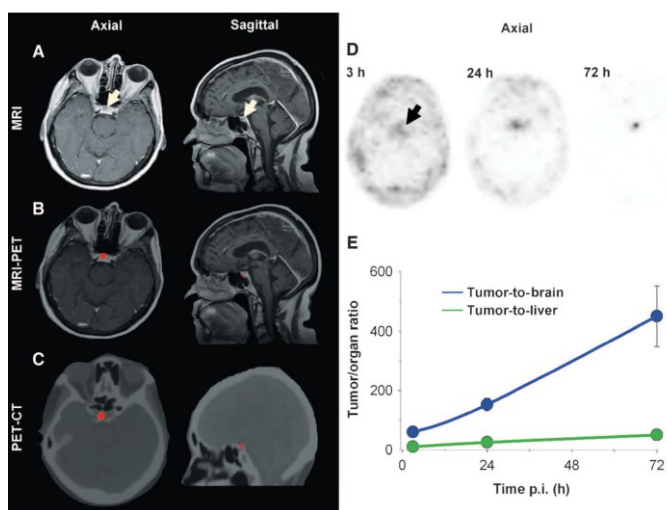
Clinical brain PET scan for ultrasmall inorganic NPs. PET brain scan results from clinical translation of an ultrasmall inorganic optical-PET imaging NP probe. Arrows point to subcentimeter cystic focus (A) imaging 72-hours after NP injection. (B) MRI-PET (C) PET-CT (D) axila PET images of ¹²⁴I-cRGDY-PEG-C dots in the brain 3-, 24- and 72-hours p.i.. Study found higher tumor-to-brain activity observed as time went on. (E) time (hours) vs tumor/ organ ratio for ¹²⁴I-cRGDY-PEG-C dots. Image taken from Clinical translation of an ultrasmall inorganic optical-PET imaging NP probe.¹³⁸ Permission granted through Rightslink®.
